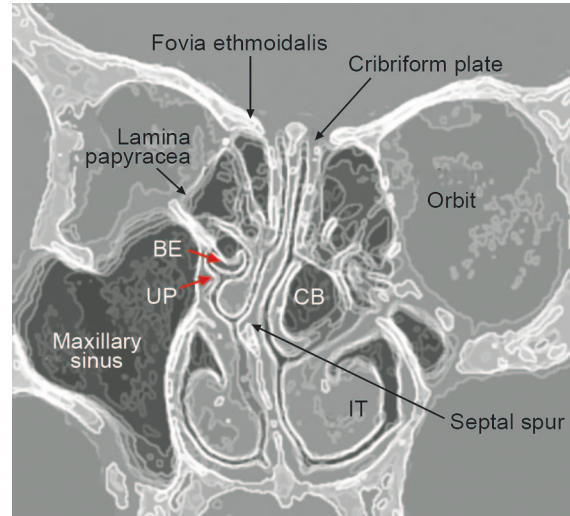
Same CT restructured showing the details—uncinate process (UP), bulla ethmoidalis (BE), pneumatized middle turbinate or concha bullosa (CB), inferior turbinate (IT)
